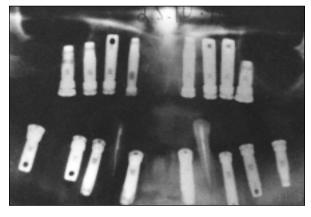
Panoramic radiograph at stage 1 after tooth extraction and immediate implant placement.
